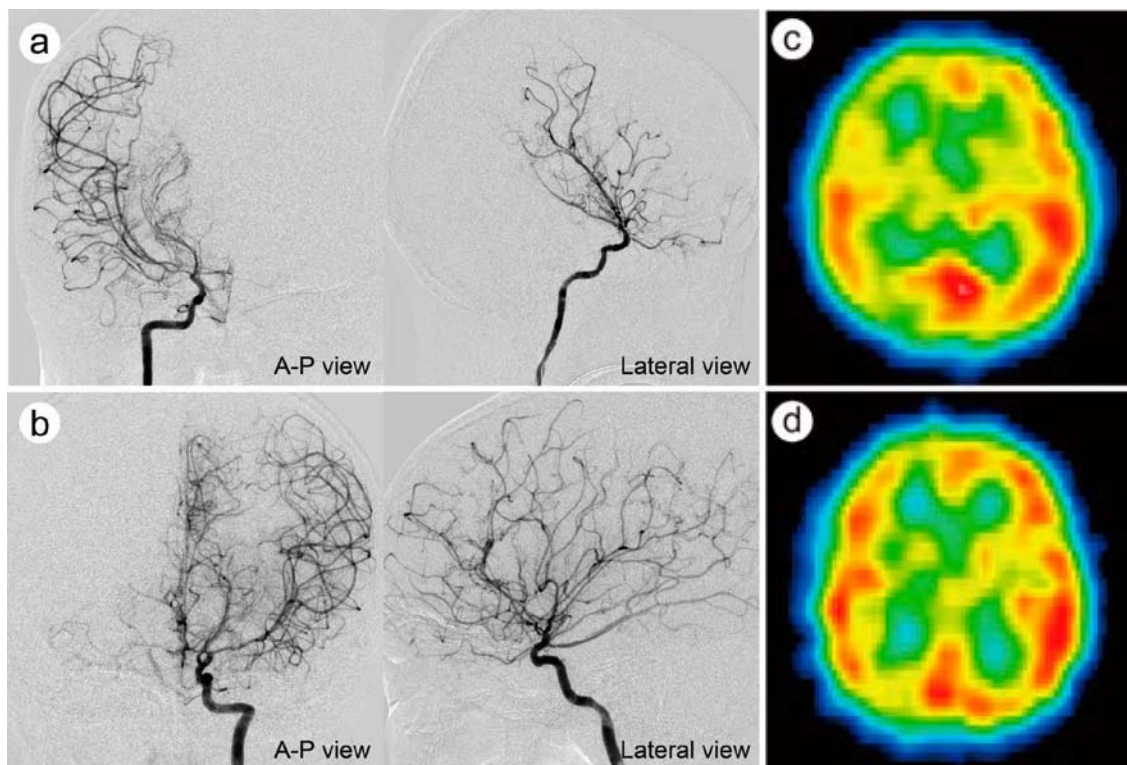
Digital subtraction angiography demonstrates stenosis of the terminal position of the internal carotid artery, proximal position of the anterior cerebral artery and middle cerebral artery with well-developed moyamoya vessels (a: right, b: left). Initial hemodynamic assessment using single photon emission computed tomography shows a decrease in cerebral blood flow in the right anterior middle cerebral artery territory (c), which improved at 4 months after right bypass surgery (d). A-P: anterior-posterior.
